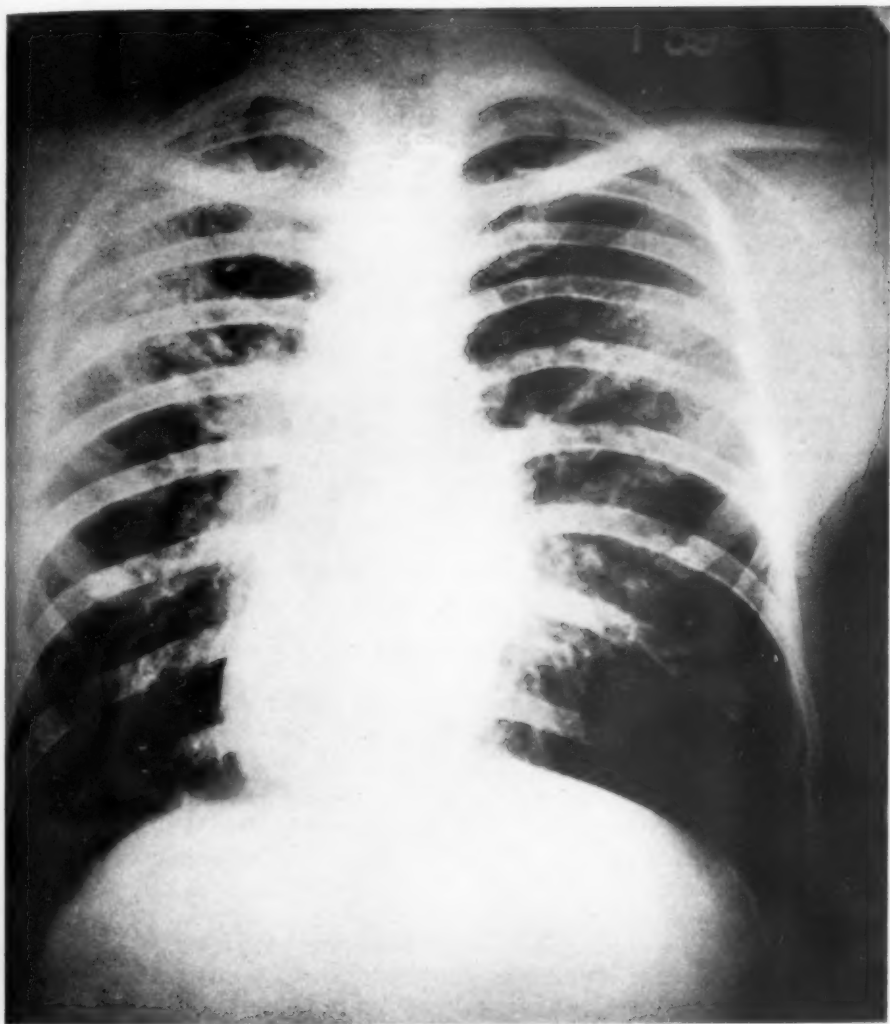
Roentgenogram of chest, June 22, 1934.
